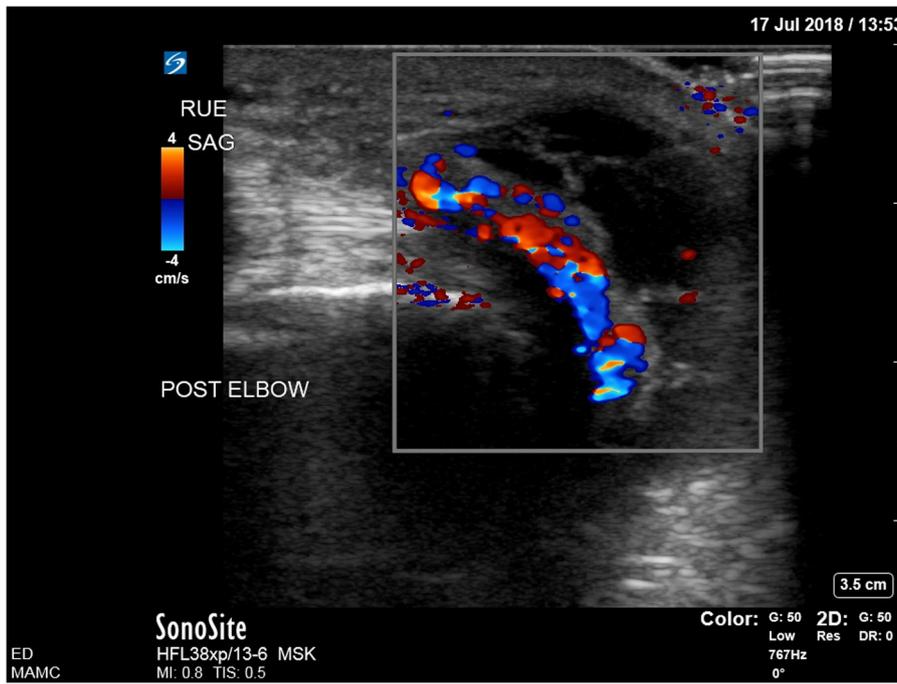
Saggital view of avascular fluid collection within right posterior elbow with Doppler imaging.
